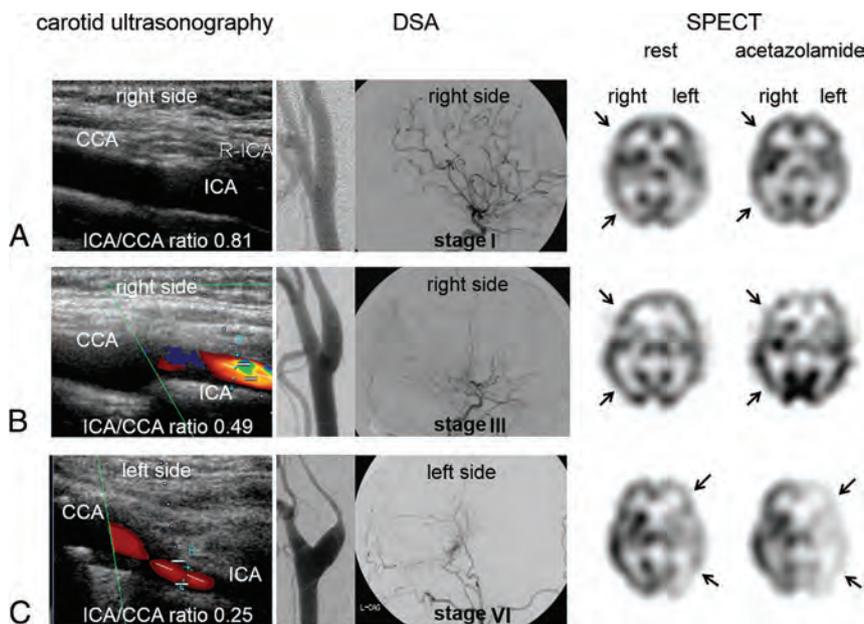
Representative cases. The left, middle, and right columns show the features of carotid ultrasonography, a lateral view of DSA of the carotid and intracranial arteries, and an axial SPECT image from 3 cases: A, A 15-year-old girl had a Suzuki stage I artery on the right (asymptomatic) and a stage II artery on the left (symptomatic). The CBNS was negative on the right by carotid ultrasonography and DSA, with preserved CVR (arrows). B, A 37-year-old woman had a stage III artery on the right (symptomatic) and a stage IV artery on the left (asymptomatic). The CBNS was positive on the right, with a mildly decreased CVR (arrows). C, A 58-year-old woman had a stage II artery on the right (asymptomatic) and a stage VI artery on the left (symptomatic). The CBNS was positive on the left, with a markedly decreased CVR (arrows).
